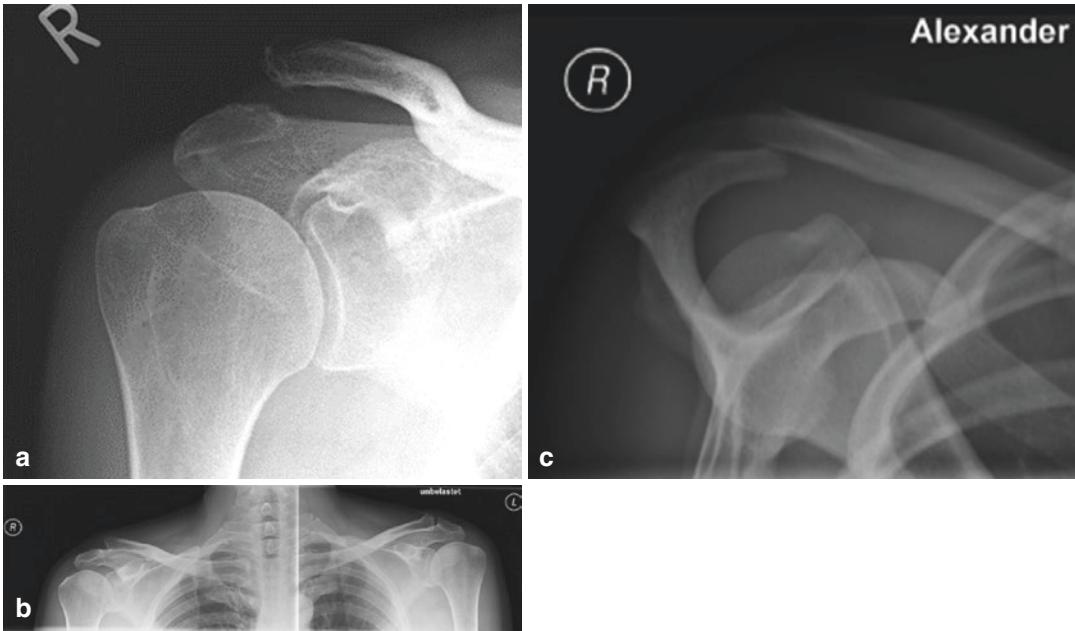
X-Ray in three planes ((a) AP view; (b) bilateral Zanca view; (c) Alexander view) of a patient presenting with Rockwood type IV instability. Note the different
